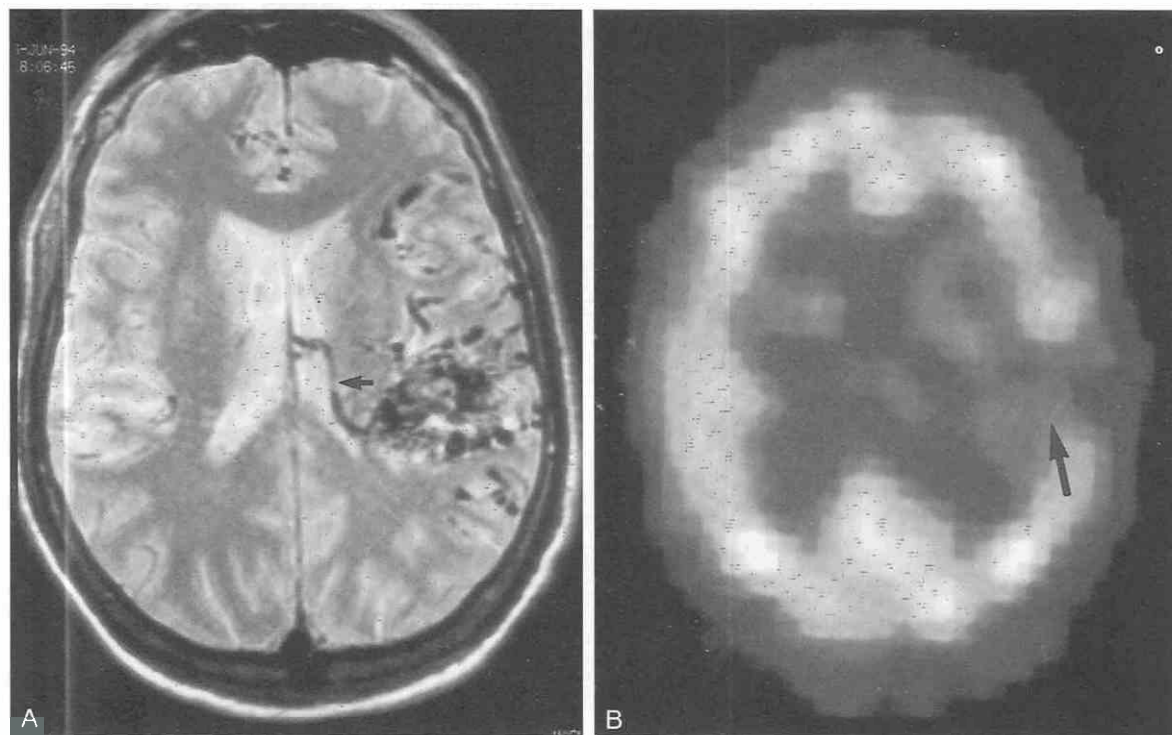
A, Axial T2-weighted MR image demonstrates an AVM with venous drainage to an enlarged left thalamostriate vein (arrow). B, Axial Cerectec SPECT brain scan demonstrating diminished cerebral perfusion within the AVM (arrow).
